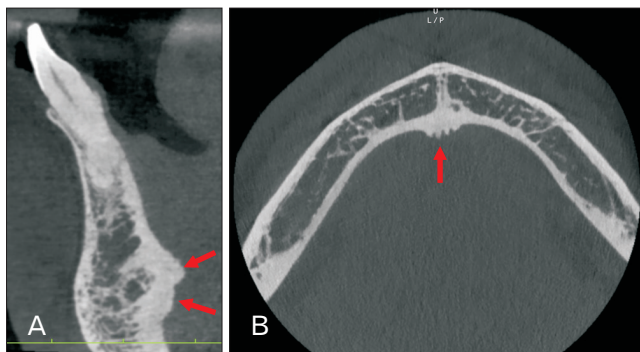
(A) Midsagittal and (B) axial cone-beam computed tomography of the mental spines (arrows).
